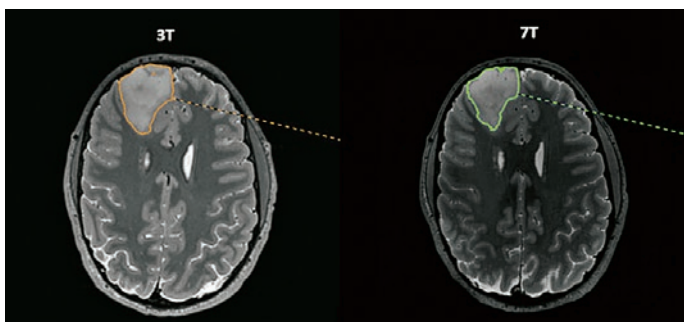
Presentation of glioma delineation in the frontal lobe on 3T and 7T MRI
